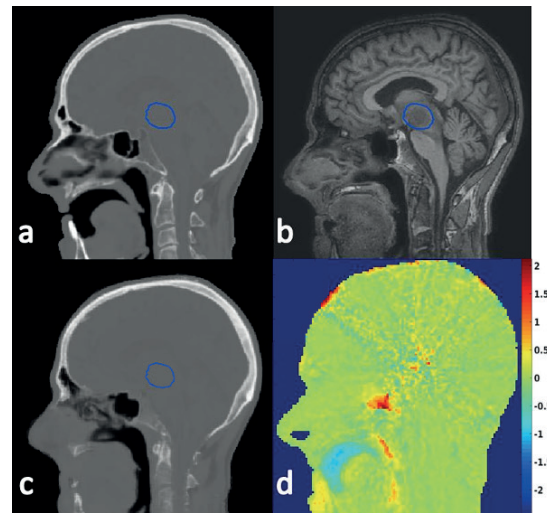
Sagittal slice of a patient with a metastasis in the brain stem (PTV shown). CT (a), MRI (b), sCT (c) and dose difference, in % of PD = 24 Gy (d). Note the difference in position of the tongue on CT and MRI. Differences in body contour and air cavities also result in dose deviations.
